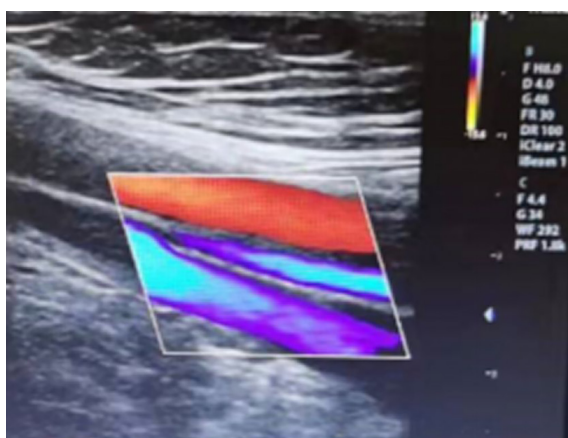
Color Doppler ultrasound for lower limb vascular for the patient on Dec 9th.
